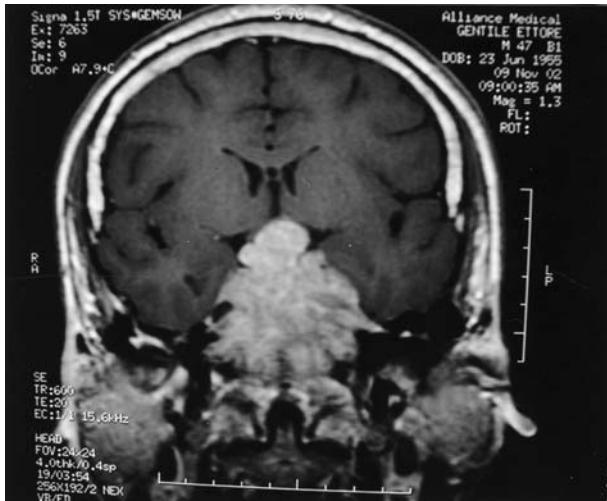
Case II: Coronal section of a T1-weighted magnetic resonance image showing a pituitary macroadenoma.
